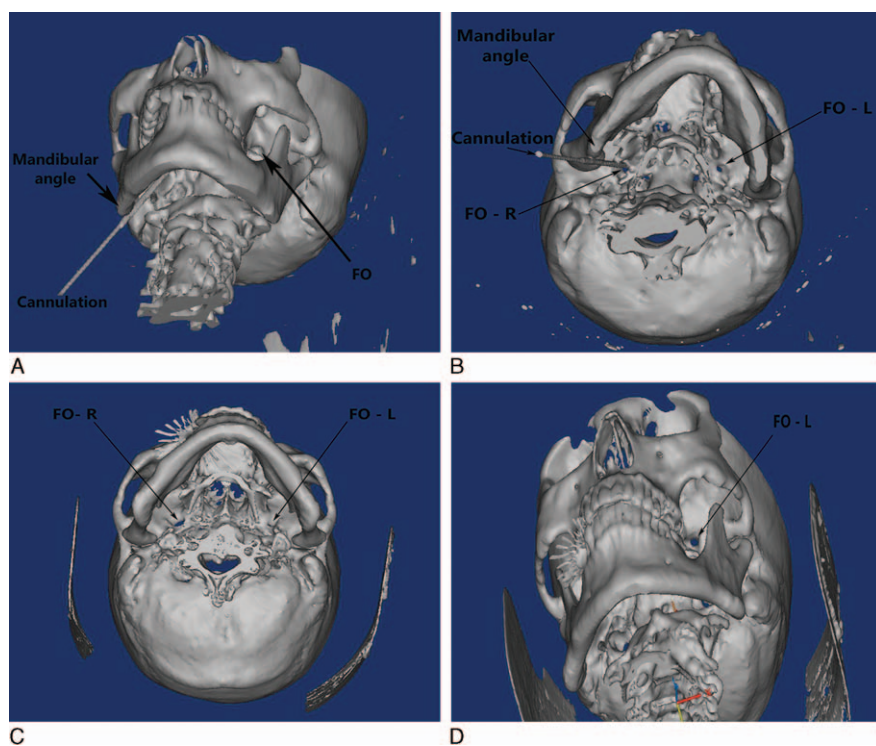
(A) Photograph. CT image reconstruction showing a caudally oriented FO. (B) Photograph. Cannulation was not successful through either the right or left FO using Hartel anterior approach. Cannulation through the FO was only possible using a submandibular trajectory. (C) Photograph. CT image reconstruction showing that the angle of the opening on the left side of the FO was anterolateral. (D) Photograph. Cannulation through this FO was only possible using Hartel anterior approach.
